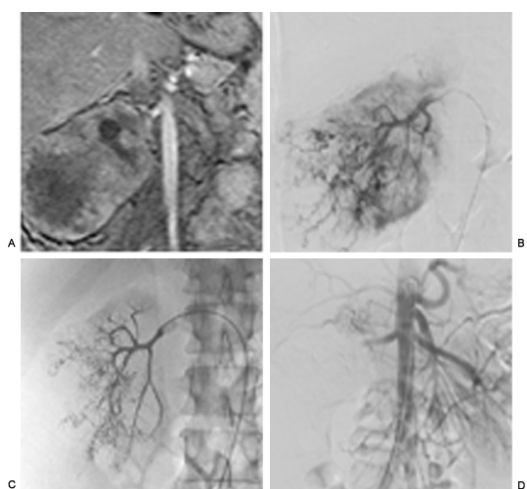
2. This patient is a 56-year-old man with right flank mass and hematuria. A: Magnetic resonance imaging scan demonstrates renal cell carcinoma fed by enlarged renal artery. B: Digital subtraction angiography confirms single renal artery. C: Absolute alcohol is used to embolize tumor preoperatively. Occlusion balloon is in place to prevent reflux. D: Follow-up angiogram shows no flow through renal artery.
